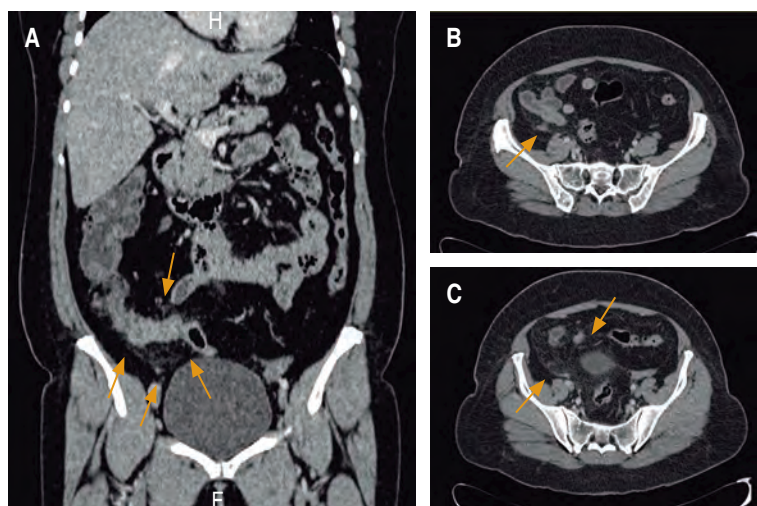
A) A CT scan coronal section, showing peripheral enhancement (arrows) of the mucosa of the small bowel loops and changes due to striation of the adjacent fat. B) An abdominal CT scan axial section, after the administration of contrast material, showing an increase in the density of mesenteric fat in the location of the right iliac fossa adjacent to the cecum (arrow), as well as peripheral enhancement of the mucosa of the same structures, which is associated with multiple images of nodular aspect corresponding to nodes of inflammatory features. C) Inflammatory changes of the mesenteric fat (arrows) extending towards the pelvic bone.
